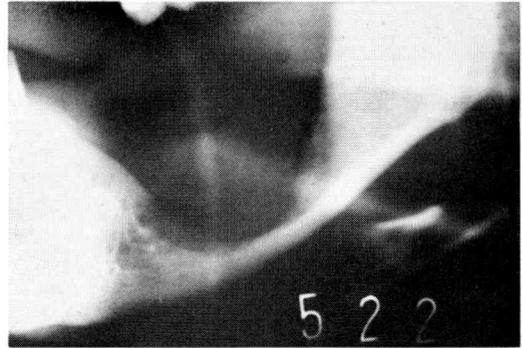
A panoramic x-ray film after the operation. The inferior margin of the mandible barely remains, which serves to retain the shape and function of the mandibular part of the face.
